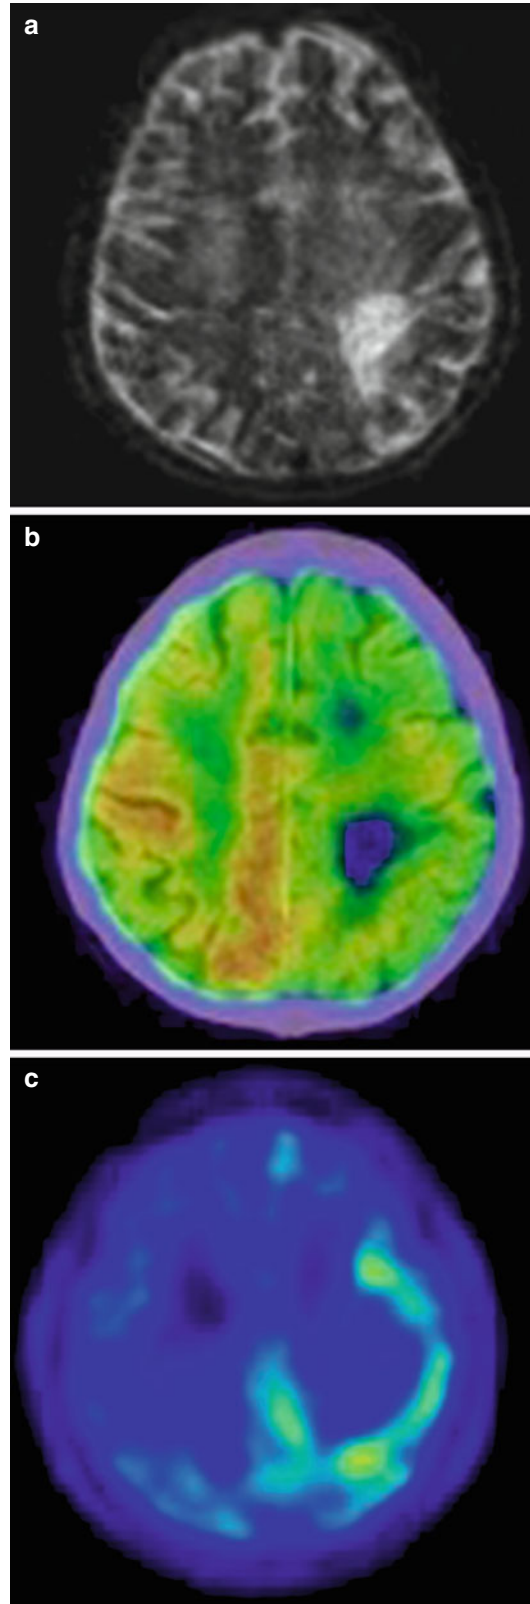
Examples of ^{11}C -methionine (^{11}C -MET) and [^{18}F]FDG findings in the diagnosis of progressive multifocal leukoencephalopathy. Brain MRI image on admission (T2-weighted image) showing leukoencephalopathy of the left parietal lobe (a). [^{18}F]FDG uptake is decreased inside the lesion (b). ^{11}C -MET uptake is increased around the lesion (c) (Adapted from Shirai et al. [149])
